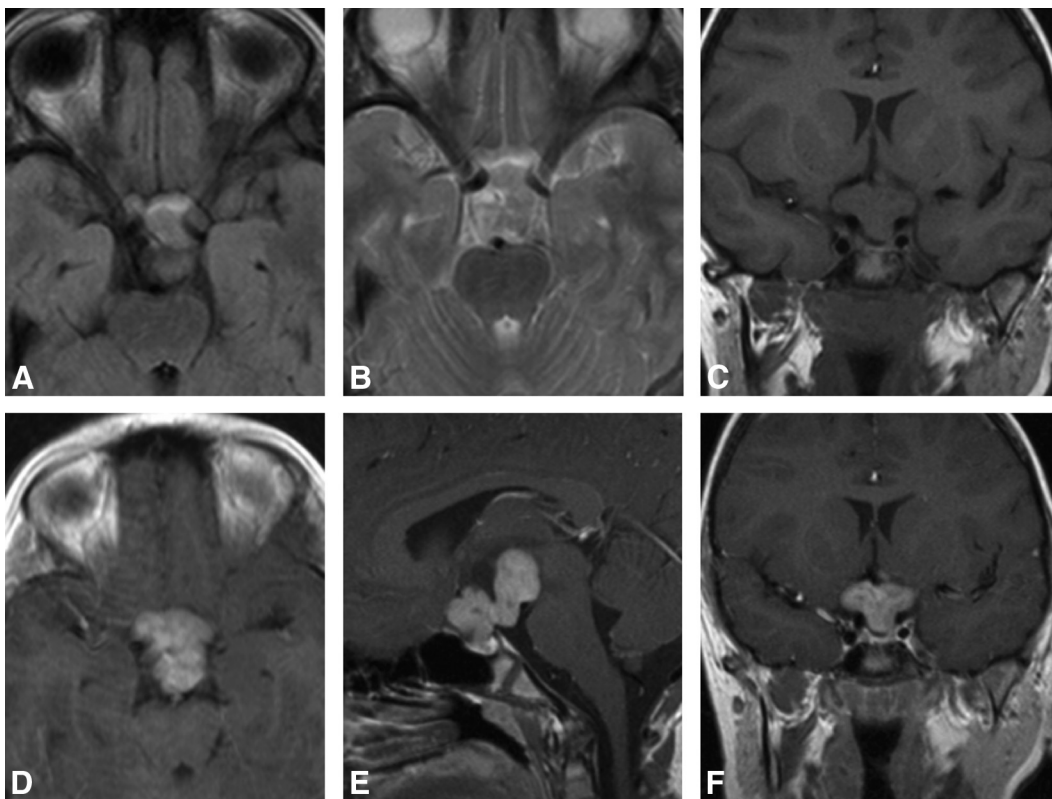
Germinoma. Axial FLAIR (A) and T2WI (B); coronal T1WI (C); and postgadolinium axial (D), sagittal (E), and coronal (F) T1WIs of a germinoma. An 11-year-old child with a history of polyuria, polydipsia, and vision loss. MR imaging demonstrates a suprasellar mass with a lobulated appearance that enhances homogeneously. The optic chiasm is difficult to separate from the mass.
